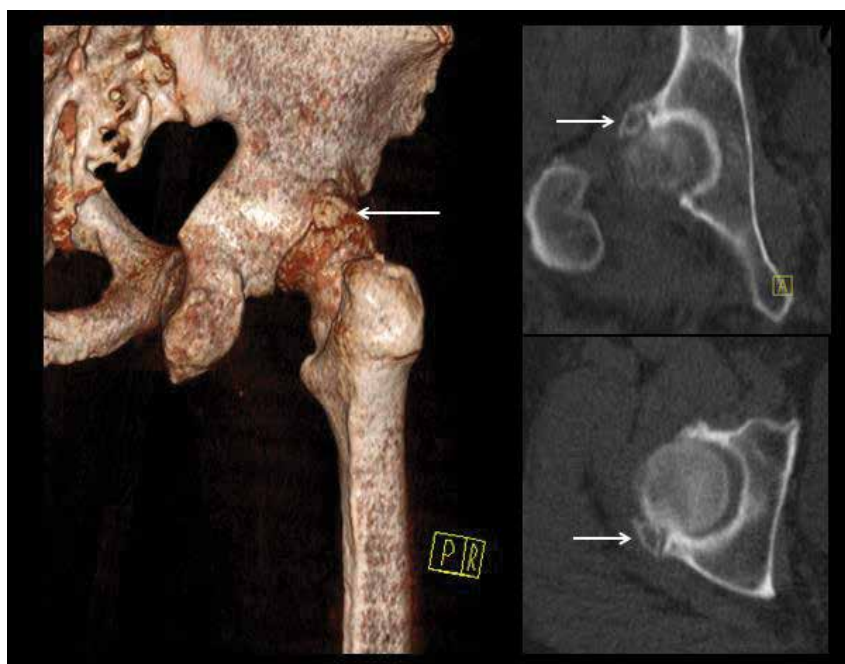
Coronal and axial CT and volume rendering of the hip joint shows fragment of acetabular labrum, clearly defining the labral tear.
